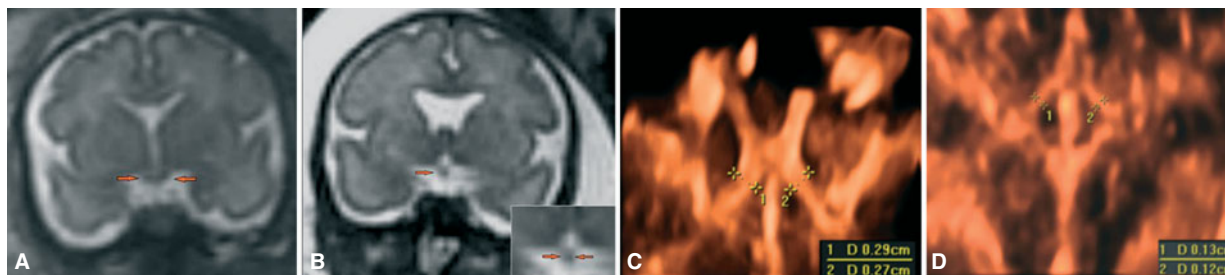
Demonstration of fetal optic chiasm. MR coronal sections demonstrating a normal chiasm (arrows) (A) compared with a hypoplastic one (arrows) in one fetus with septo-optic dysplasia. Three-dimensional sonograms demonstrating measurement of the posterior tracts in a normal optic chiasm (C) compared with a hypoplastic one (D). (A, B Reproduced from Lepinard C, Coutant R, Boussion F, Loisel D, Delorme B, Biquard F, et al. Prenatal diagnosis of absence of the septum pellucidum associated with septo-optic dysplasia. *Ultrasound Obstet Gynecol.* 2005 Jan;25(1):73–75.) (C, D Reproduced from Damaj L, Bruneau B, Ferry M, Moutard ML, Garel C, Odent S, Adamsbaum C, Avni F, Tréguier C, Lazaro L: Pediatric outcome of children with the prenatal diagnosis of isolated septal agenesis. *Prenat Diagn.* 2010;30(12-13):1143–1150.)
